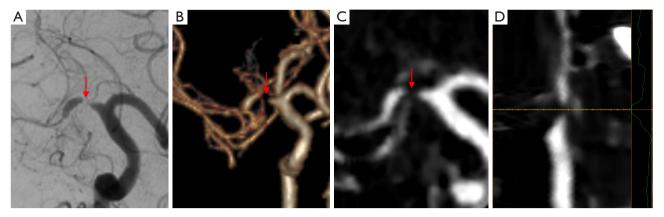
An example of 99% stenosis. An adult patient with a symptomatic right middle cerebral artery stenosis. The 99% stenosis showed a gap sign (red arrows) on DSA (A), CTA (B) and semi-automatic vessel analysis software (C,D). DSA, digital subtraction angiography; CTA, computed tomography angiography.
